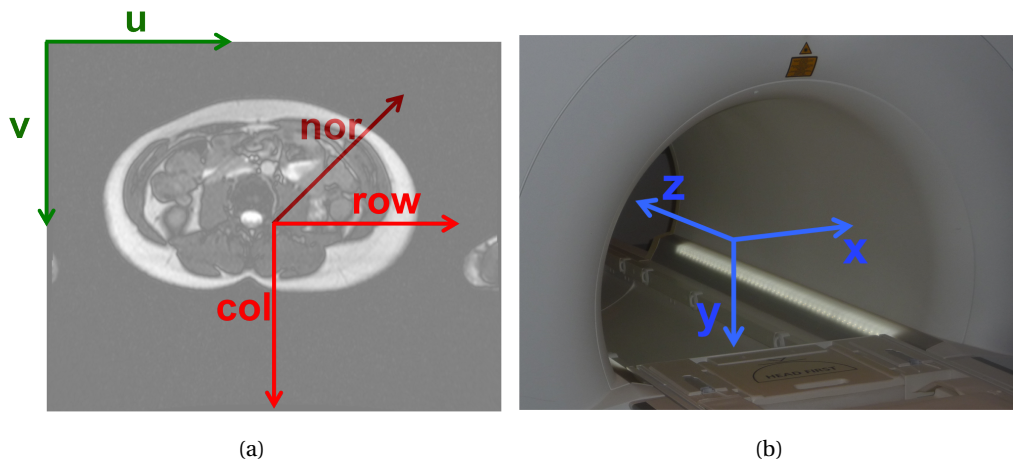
Image and Machine coordinate systems used during this work. (a): Coordinate systems  $\mathcal{F}_C$  and  $\mathcal{F}_I$ , both linked to the image plane are represented. (b): Coordinate system linked to the MRI scanner  $\mathcal{F}_M$  is represented.
